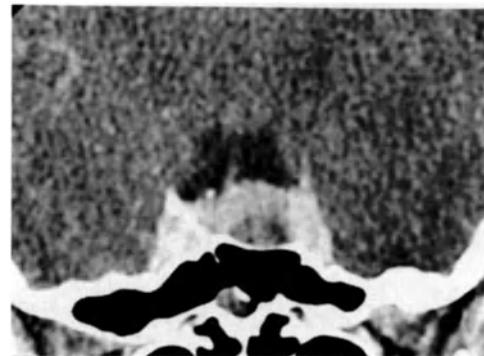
Pituitary microadenoma shown by CT. The low density microadenoma is also bulging the floor of the sella.
